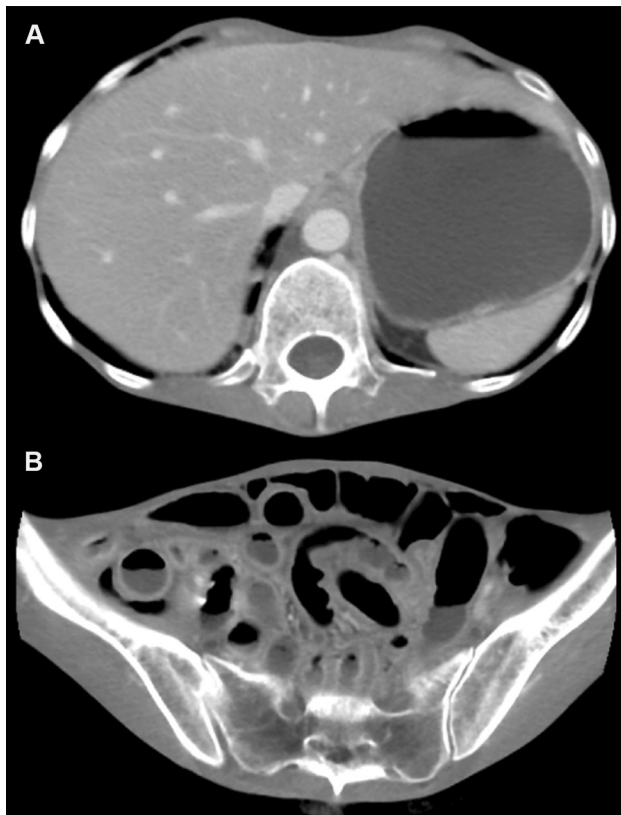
Abdominal CT scan showing massive gastric dilatation (a) and distended bowel loops (b)
